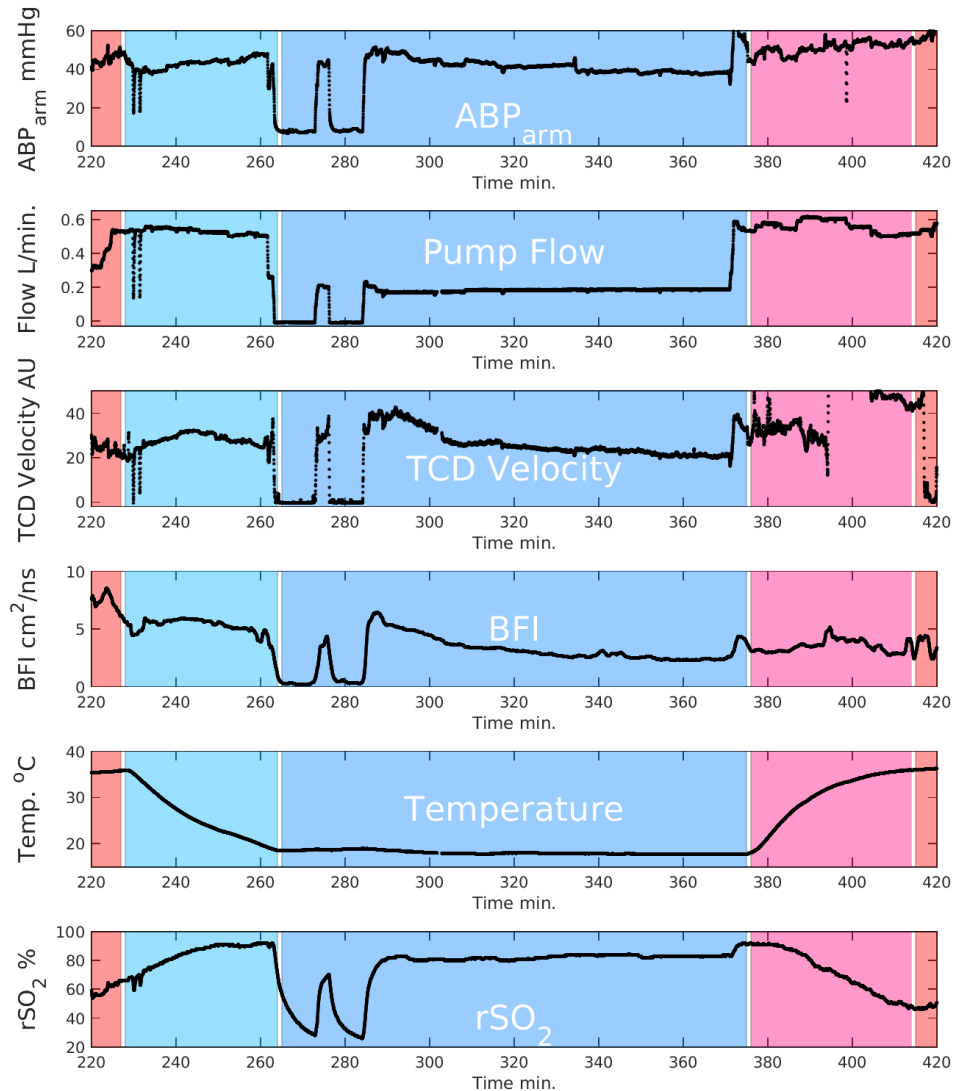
Time traces of pump flow, arterial blood pressure, TCD ultrasound blood velocity, DCS Blood Flow Index, temperature, and rSO<sub>2</sub> from an INVOS cerebral oximeter. Normothermia, cooling, DHCA, rewarming, and return to normothermia are designated with shaded regions. Data were filtered with a 10-second moving window; motion artifacts were discarded. Note that the rewarming period had significant motion artifacts due to clinical manipulations.
